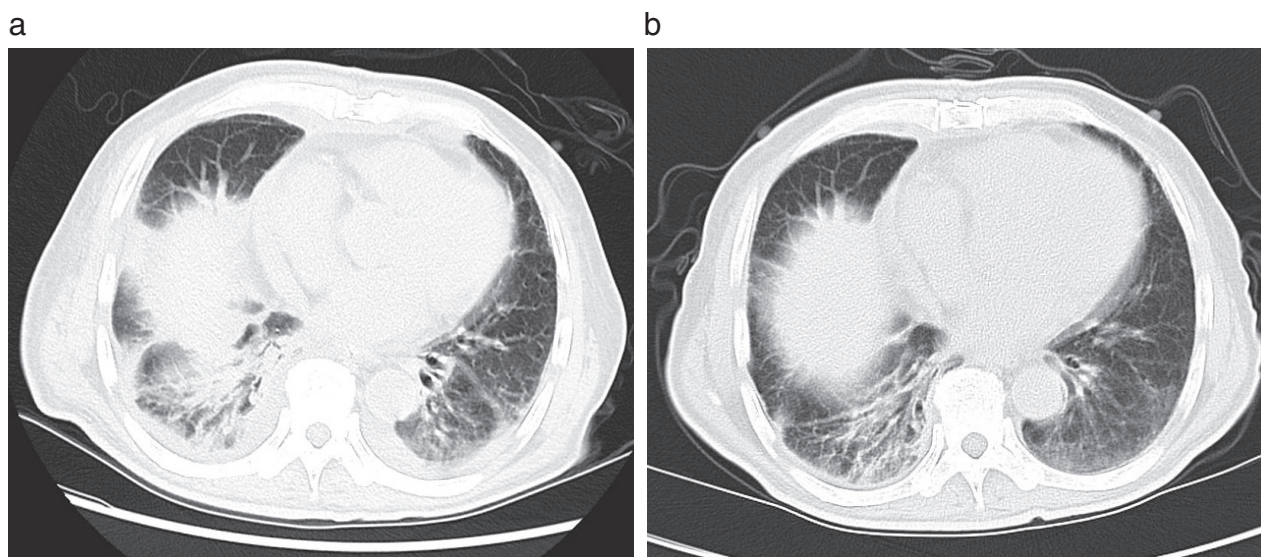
Computed tomography (CT) images of interstitial pneumonia showing (a) Improvement postoperatively after two weeks, and (b) dramatic improvement postoperatively after three weeks.
